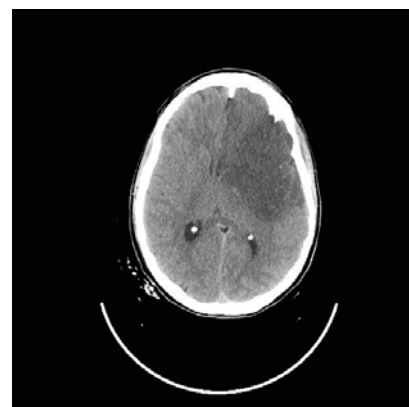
Urgent cranial CT (axial section): extensive hypodense area, extending into the territory of the left MCA and the anterior cerebral artery with hyperdensity of the M1 segment of this artery in relation to ischemic injury in the subacute phase. A mass effect was observed with compression of the left ventricular lateral horn and minimal subfalcal herniation.
